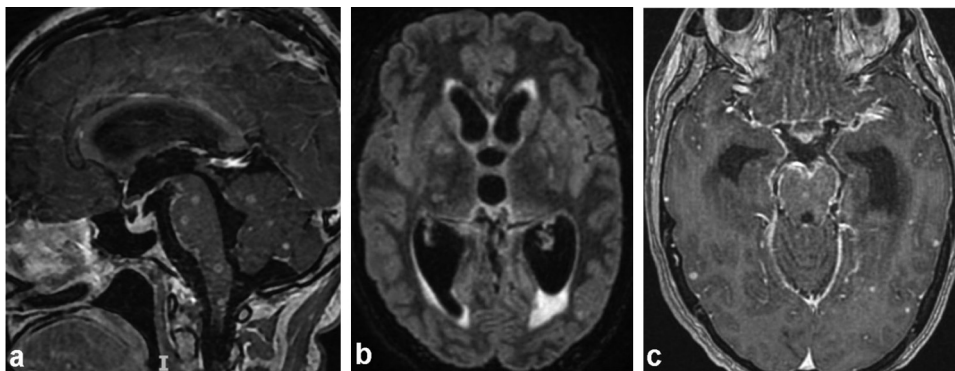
a. T1 MRI after gadolinium infusion, sagittal. Hyperpressure hydrocephalus with fourth ventricular and cisterns dilatations. Note the multiple nodular parenchymatous enhancements. b. T2/FLAIR MRI, axial. Ventricular dilatations involving lateral and third ventricles. c. T1 MRI after gadolinium infusion, axial. Leptomeningeal arachnoiditis and dilatation of the temporal horns of the lateral ventricles.
